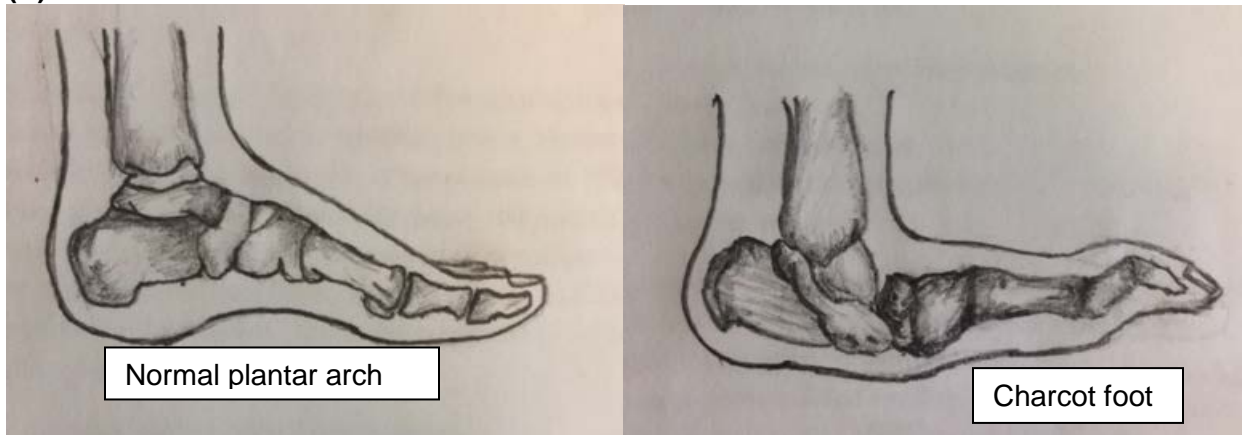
(B) The radiograph shows diffuse osteopenia, fusion of midfoot, and loss of plantar arch, consistent with neuropathic deformity of the foot.
